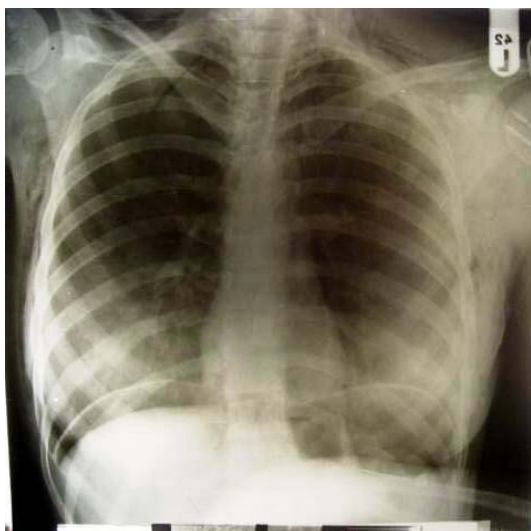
Chest x-ray showed pneumoperitoneum.
